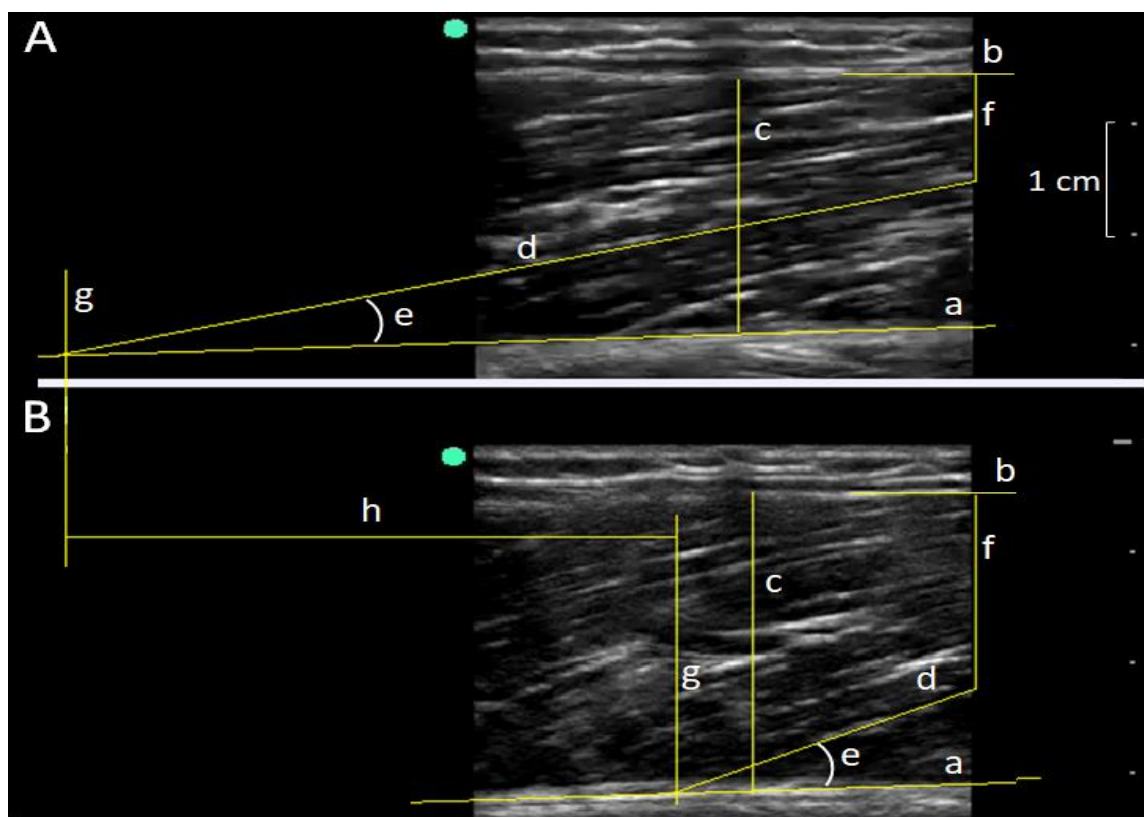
Muscle ultrasonography: An ultrasound analysis of the vastus medialis at rest (A) and during NMES-evoked contraction (B). (a) deep aponeurosis; (b) superficial aponeurosis; (c) muscle thickness; (d) fascicle with extrapolation or not; (e) pennation angle; (f) distance between end of fascicle visualization and superficial aponeurosis; (g) lines indicating the cross point between fascicle and deep aponeurosis; (h) tendon-aponeurosis complex displacement. Legend: NMES: neuromuscular electrical stimulation.
